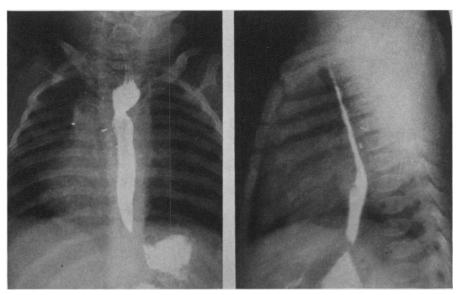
F. B., Case 26.—(A and B) Roentgenograms, six months after operation show the lumen of the esophagus to have enlarged. There was no delay in the passage of rugar through the esophagus.
